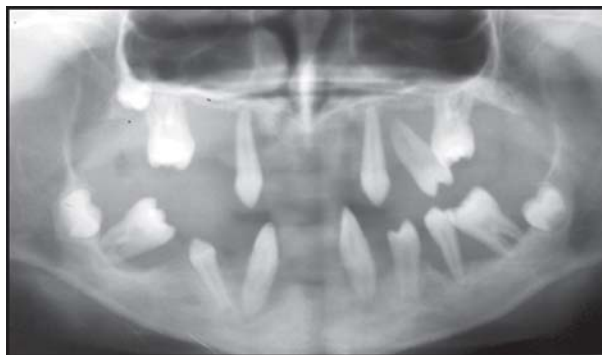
Radiograph showing loss of many permanent teeth in Generalized Aggressive Periodontitis
